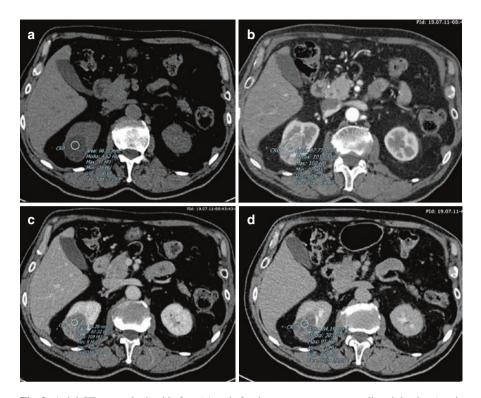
Axial CT-scans obtained before (a) and after intravenous contrast medium injection (corticomedullary phase, b; nephrographic phase, c; excretory phase, d). The ovalar-shaped endophitic right renal mass is characterized by low HU values at non-enhanced CT with strong and inhomogeneous enhancement during the corticomedullary phase. Gradual and slow contrast-enhancement wash-out is detectable in the following acquisition phases. The lesion was consistent with cc-RCC
